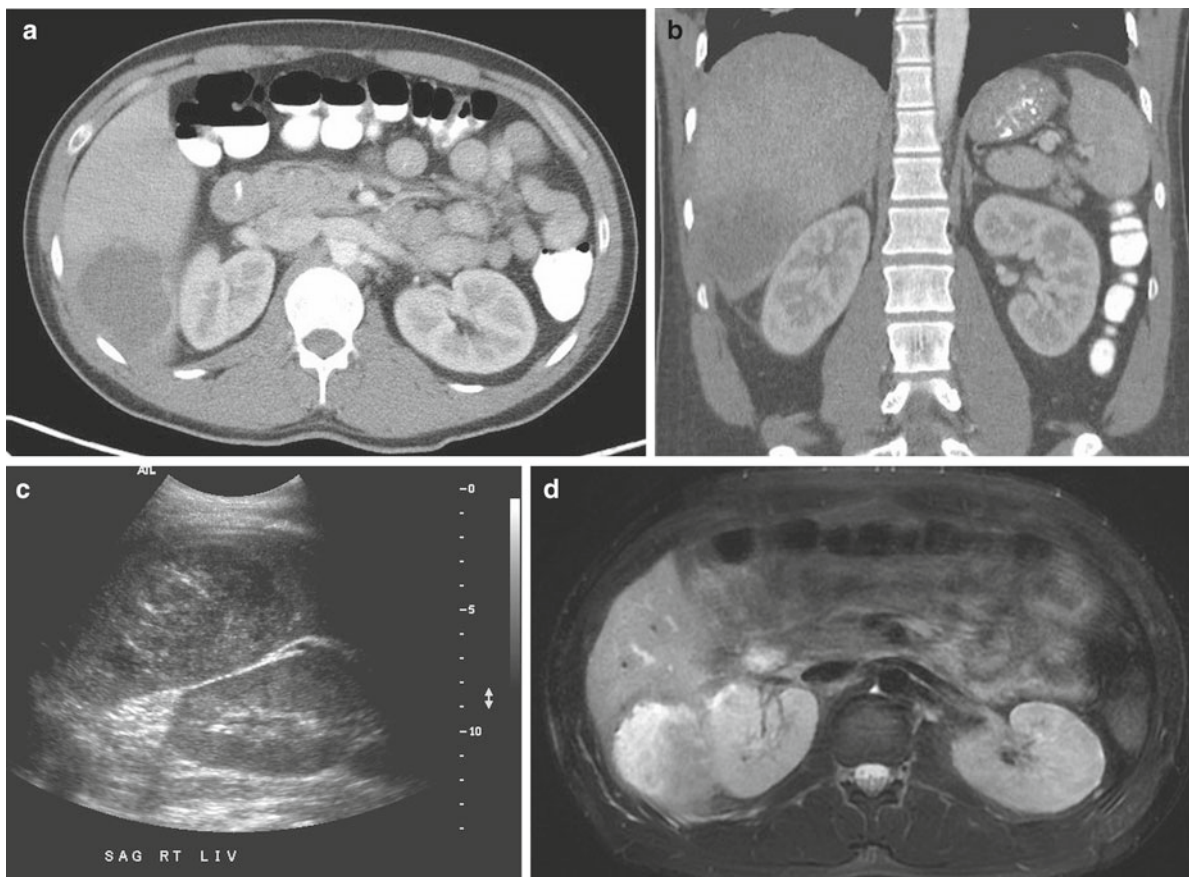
A 65-year-old woman with fever and RUQ abdominal pain. (a) Axial oral and intravenous contrast enhanced CT image through the mid abdomen shows a focal mass in the right lobe of the liver with low attenuation and slightly irregular border. (b) Coronal reconstructed CT image through the posterior abdomen shows a focal
